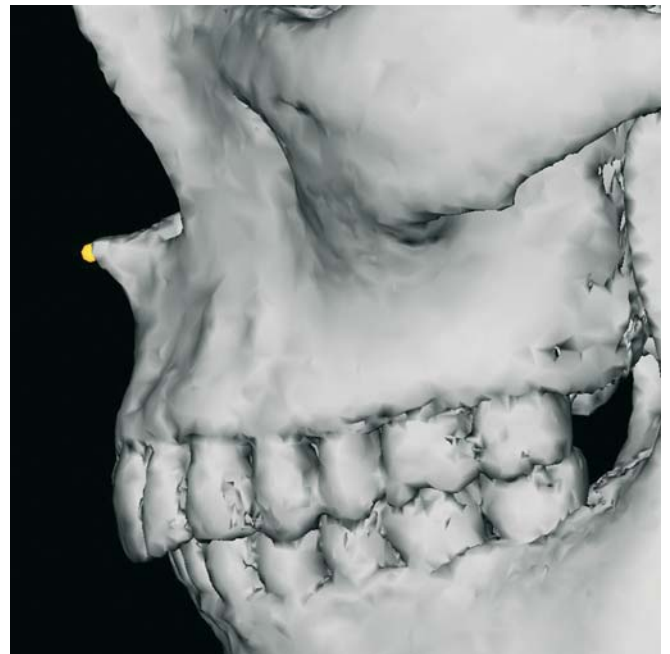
Anterior Nasal Spine. Profile view left (3-D CT, patient K.C.)
